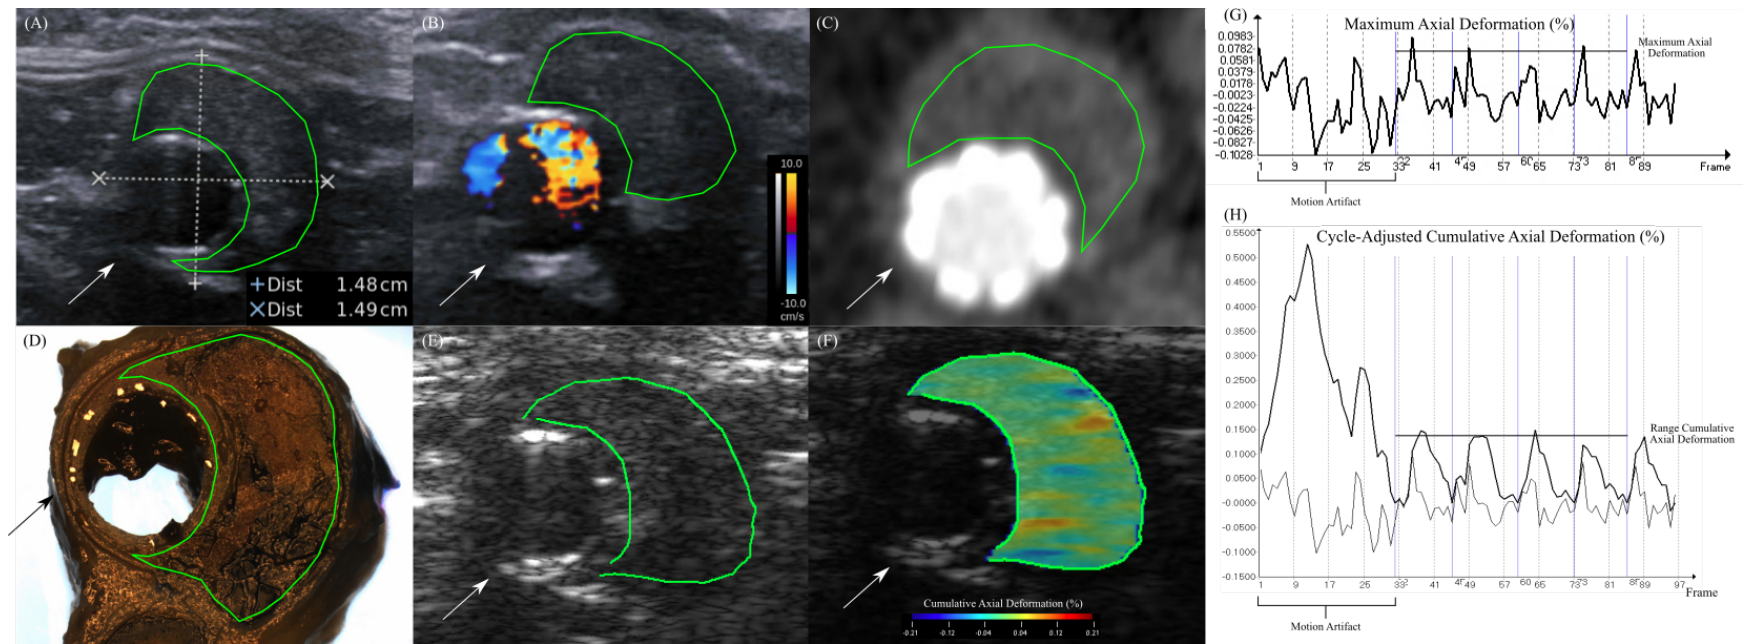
Multimodal image co-registration, segmentation, and post-processing of the aneurysm sac region of interest (segmented in green) for an aneurysm six months after successful embolization with the chitosan hydrogel embolic agent with sodium tetradecyl sulphate (CH-STs) at sacrifice. The arrows indicate the stent graft. (A) B-mode image of the distal level of the aneurysm demonstrates the segmentation of the sac. (B) Corresponding duplex ultrasound image; there is no endoleak to be excluded. (C) Corresponding contrast-enhanced CT image confirming the absence of endoleak. (D) Corresponding macroscopic cut. (E) Selected segmented B-mode image from the cine loop used to produce the elastograms. (F) Cumulative axial deformation elastogram of the sac superimposed over a cine frame during systole. (G) Instantaneous axial deformation curve; the maximum axial deformation parameter (average of all peaks) is labelled. (H) The cycle-adjusted cumulative axial deformation curve (thicker curve; the thinner curve is the axial deformation curve). The range cumulative axial deformation parameter is labelled. Note that frames containing motion artifact (seen on the cine loops) were excluded from the analysis.
